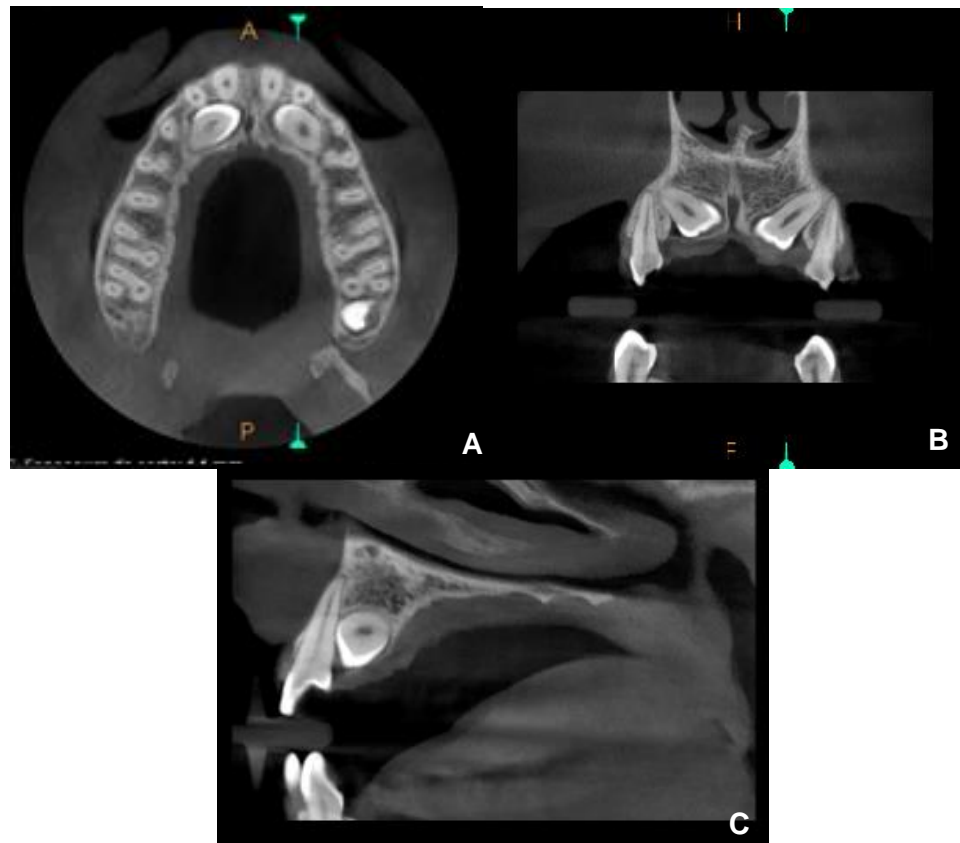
CBCT image. Root resorptions and dilacerations weren't found. A) Axial view of the 3D reconstruction image, 13 and 23 impacted palatally B) Coronal view C) Sagittal view crown positioned palatally in relation to the maxillary incisor.
